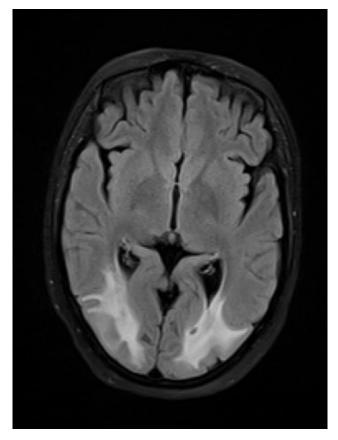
MRI Brain Axial FLAIR weighted image showing hyperintensity in bilateral; occipital lobes.
